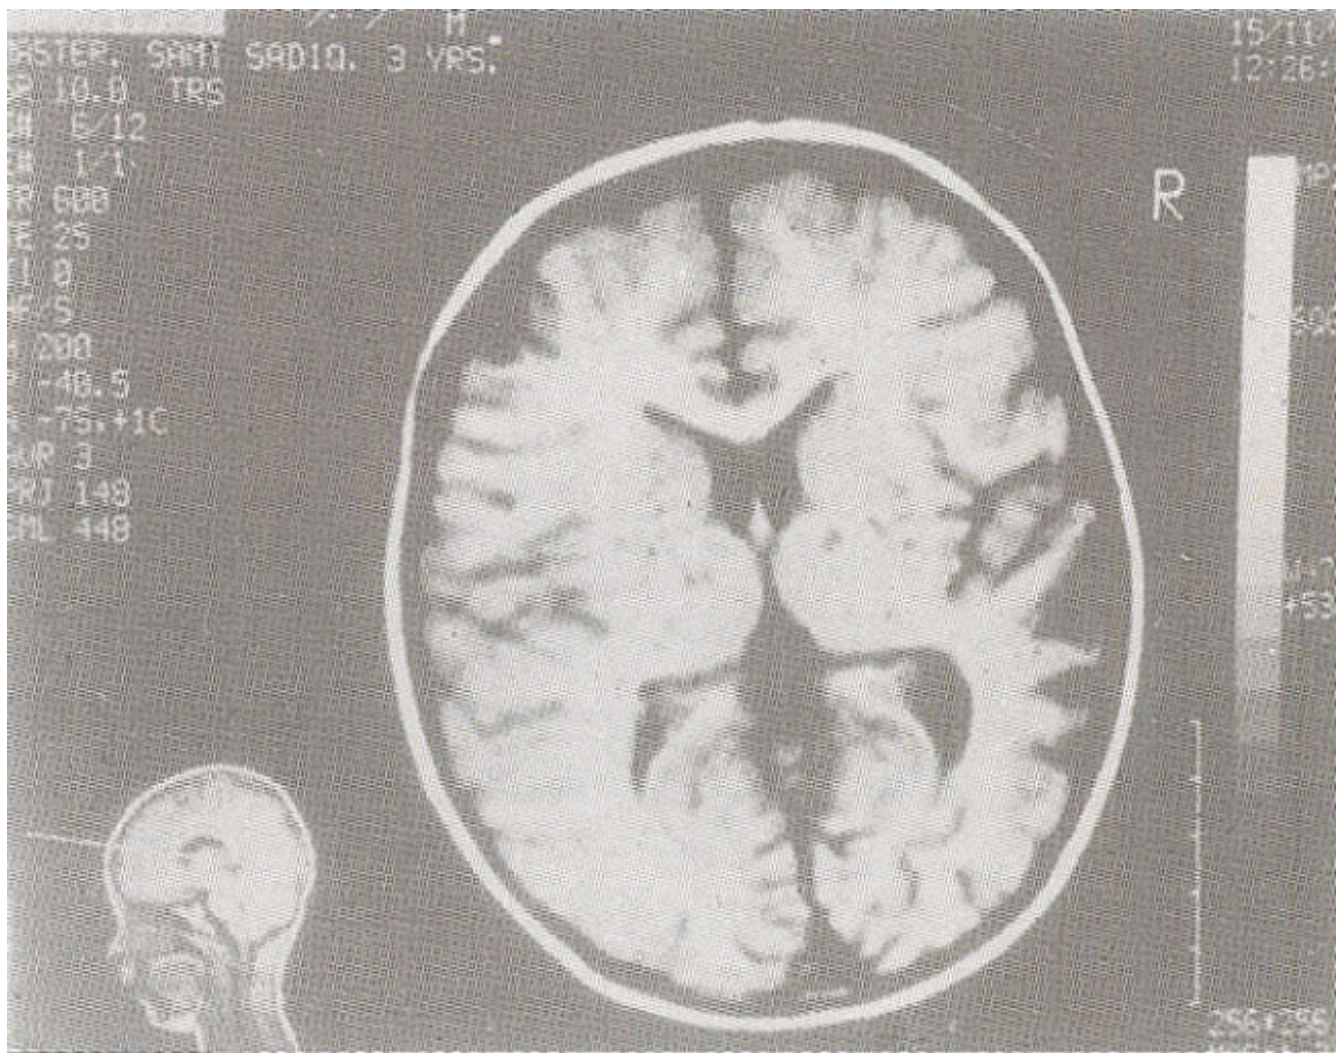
MRI showing dilated basal collateral channels in the deep grey matter.
